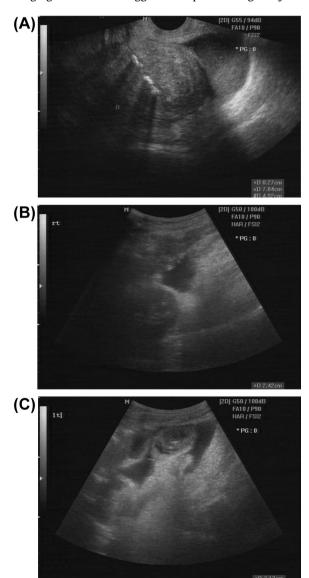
Ultrasonography showing fluid collections measuring 2.7 cm in (A) the cul-desac, 2.42 cm in (B) the right paracolic gutter, and 3.13 cm in (C) the left paracolic gutter.
